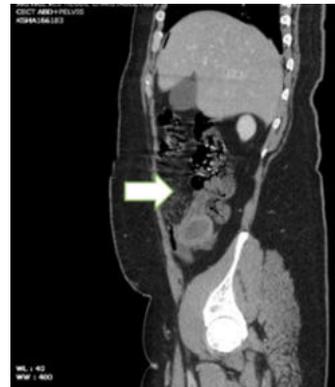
A sagittal CT image of the abdomen depicts a well-defined hypodense lesion (arrow) in the right iliac fossa.
